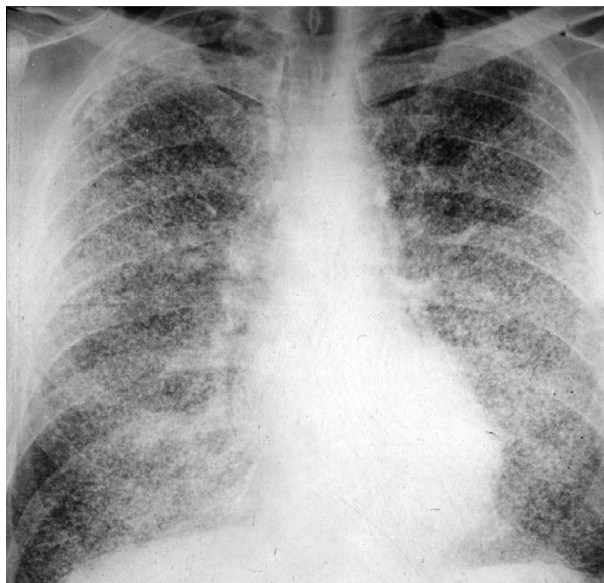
Stannosis on chest radiography. The particles of tin oxide, being radio-dense, are easily visible as small, rounded opacities throughout the lung fields—but they are biologically inert.
